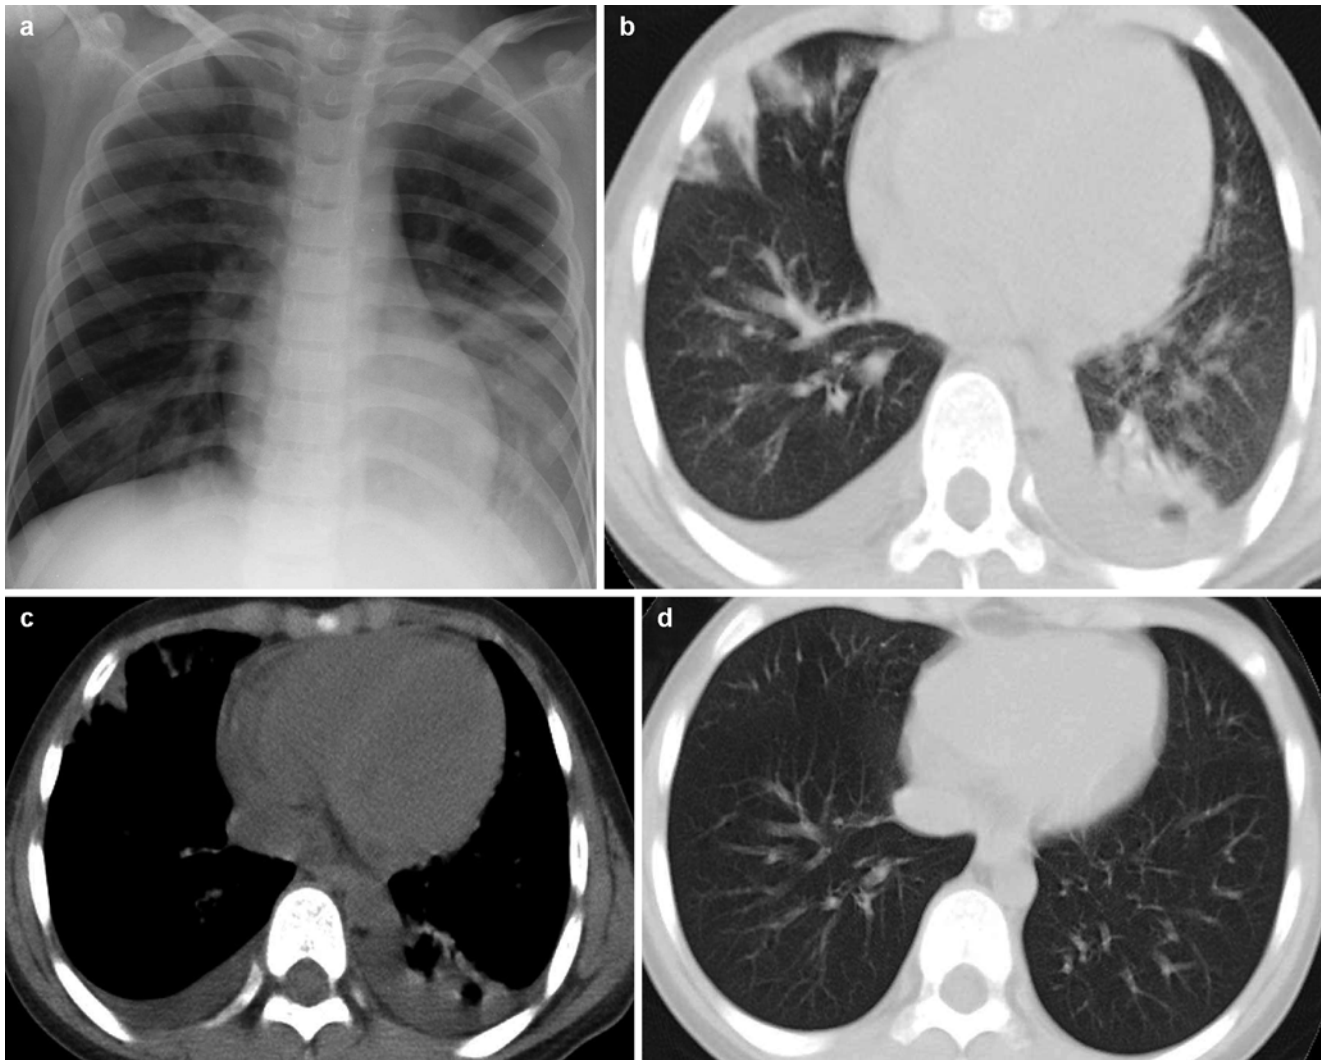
(a–d) A boy aged 6 years with a diagnosis of influenza A (H1N1) complicated by pneumonia. (a) At d 4 since onset, chest X-ray showed large high-density opacities at the left lower lung field, poorly defined left diaphragmatic surface and absence of left costophrenic angle, and patchy ground-glass opacities at the right lower lung field. (b, c) At d 5 since onset, plain CT scan (b lung window; c mediastinal
